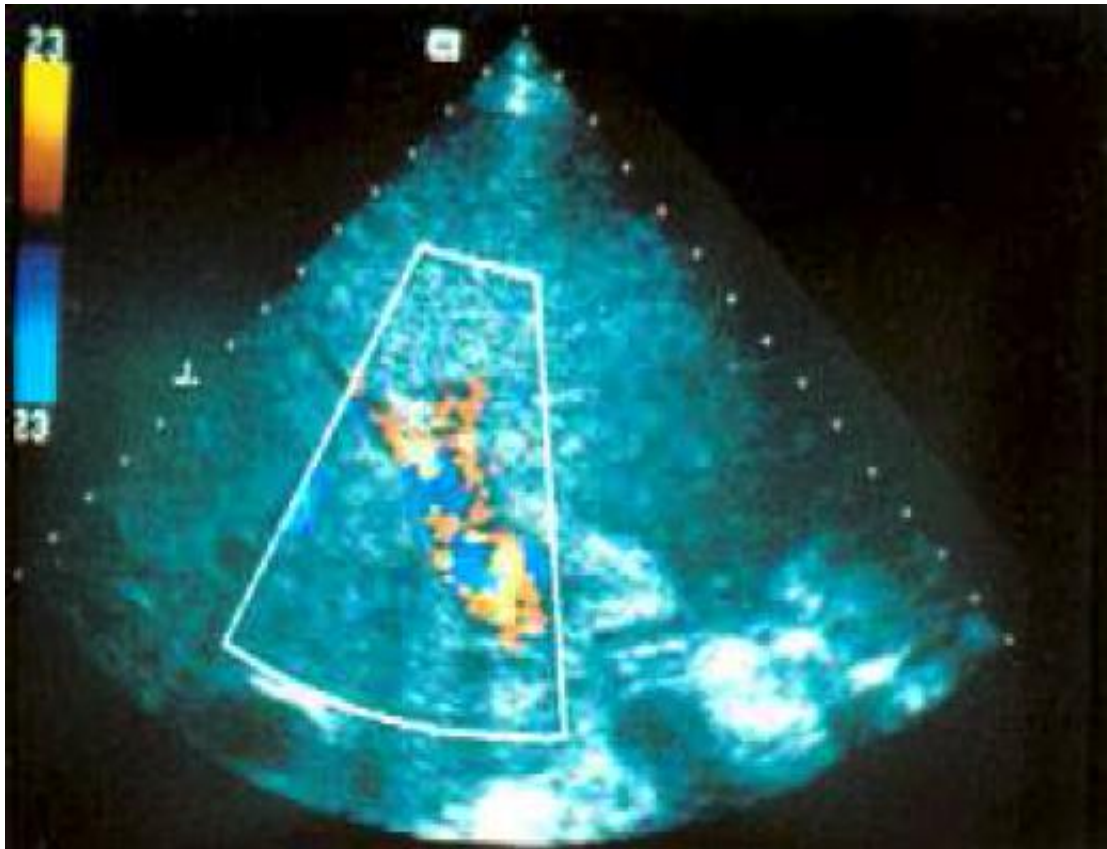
Colour Doppler US of the porta hepatis shows the hepatic artery in red and portal vein in blue
